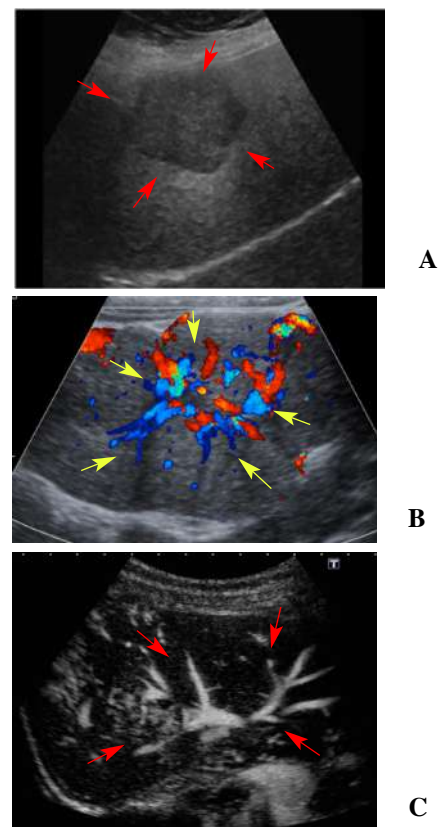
Focal nodular hyperplasia, Ultrasound Imaging (A), Doppler sonograms (B), Dynamic contrast-enhanced (C) - (arrows).
